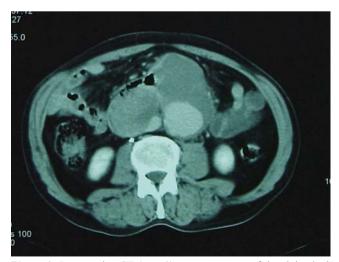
Preoperative CT (case 2): note aneurysm of the abdominal aorta, partially thrombosed, and a lateral right aortic mass.
